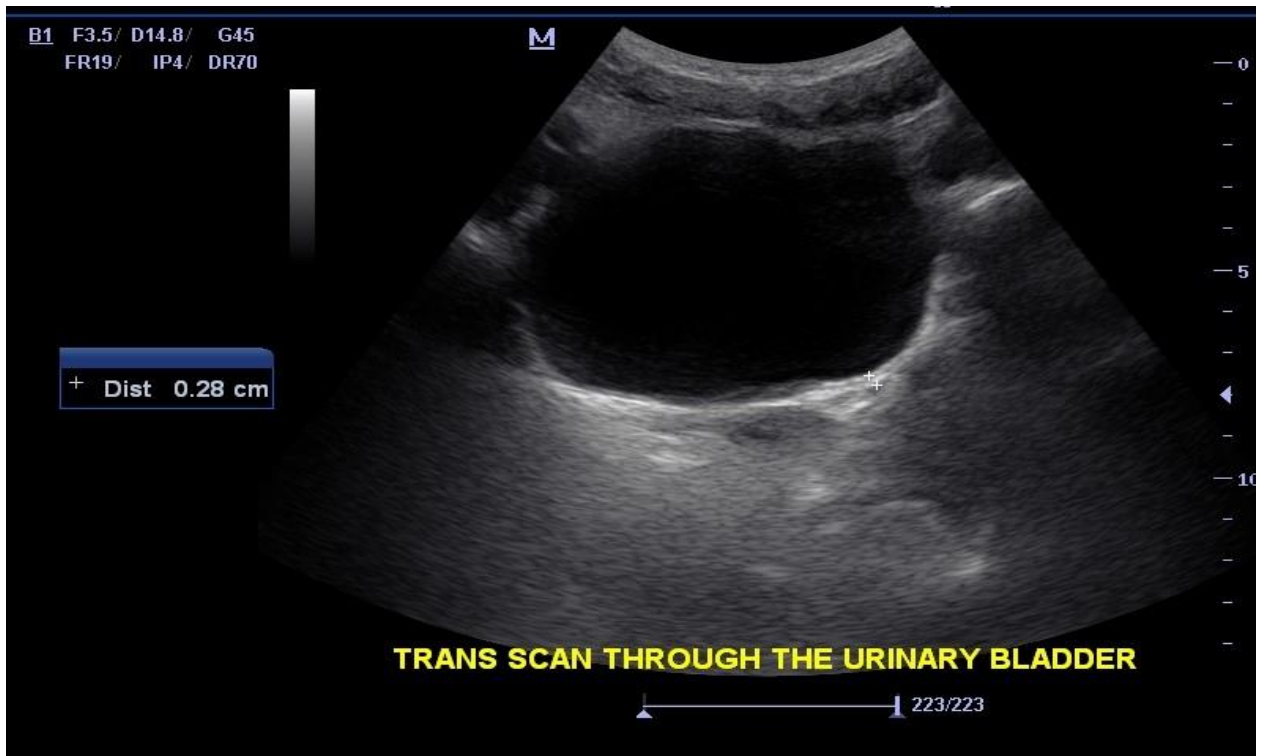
A B mode ultrasound of the bladder showing a fully extended bladder with no pathology
